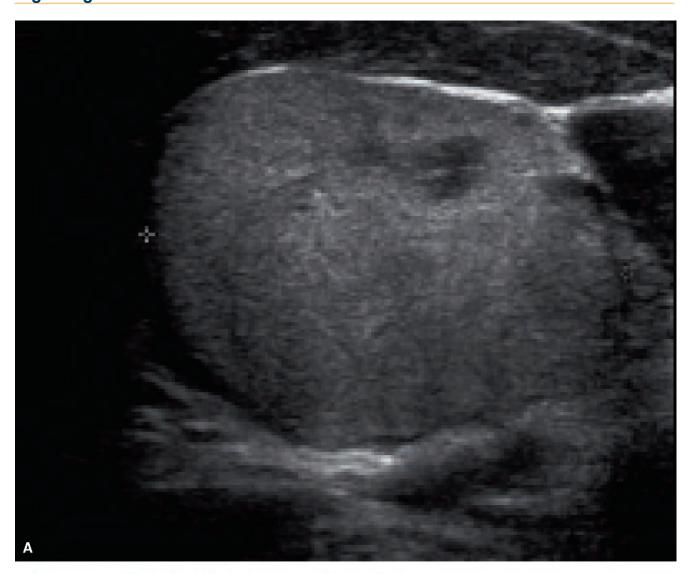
Ultrasound of lymph node metastasis from papillary thyroid carcinoma: right segment 4. A, Transverse, 26 x 37 mm. B, Color Doppler Transverse.
